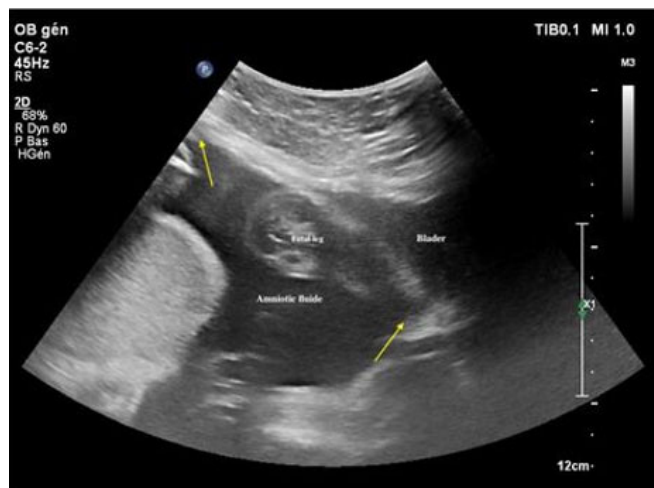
Ultrasound image of subserosal uterine rupture at 28 weeks 4 days: yellow arrows indicate the limits of the myometrium.
